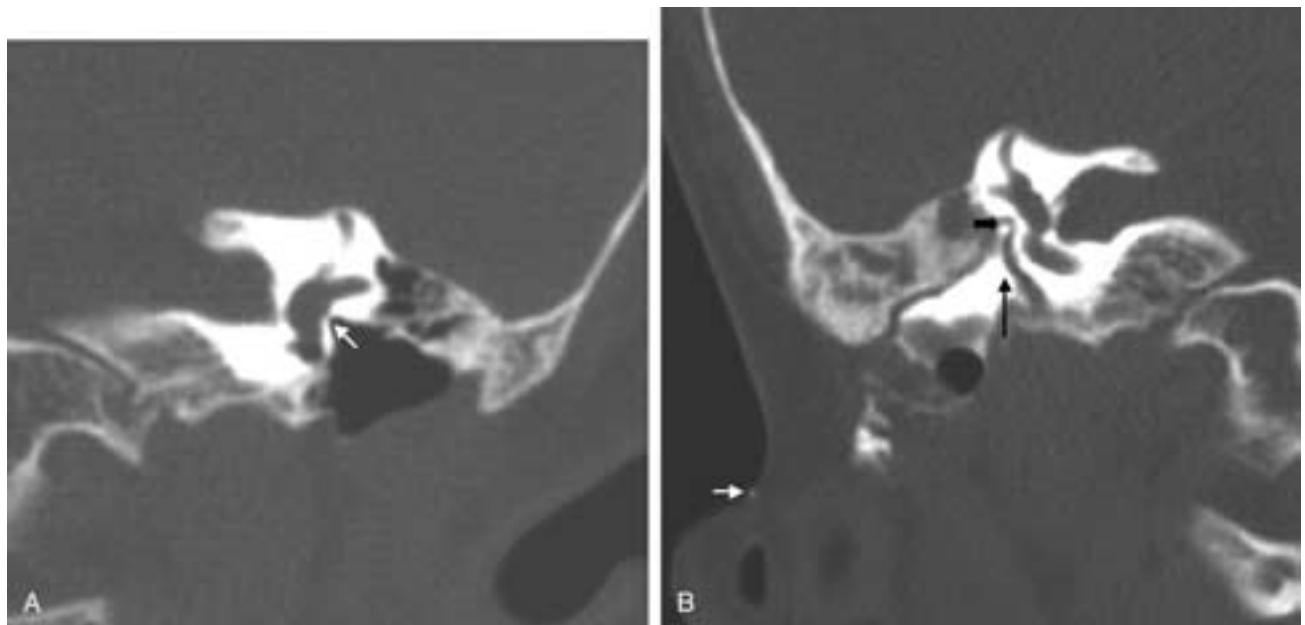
Bilateral stenoses/atresias of the oval windows and associated first branchial cleft fistula. A, Coronal CT image showing stenosis/atresia of the left oval window (*white arrow*) and possible absence of the stapes. B, Coronal CT image showing a right-sided first branchial cleft abnormality, with contrast injected from a periauricular skin opening (*white arrow*) and tracking into a stenotic middle ear cavity (*long black arrow*) up to the atretic oval window. Again, note the absence of the stapes (*short black arrow*).
